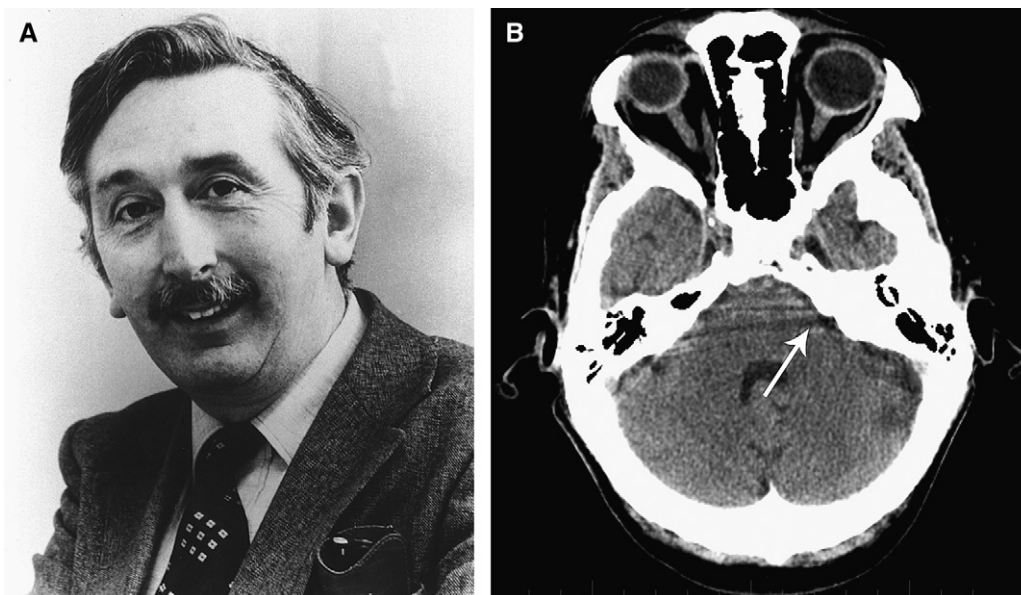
(A) Godfrey Newbold Hounsfield (1919–2004). Courtesy of the National Library of Medicine. (B) Hounsfield artifact: increased attenuation of the x-ray beam because of the density and thickness of the bone (arrow).
